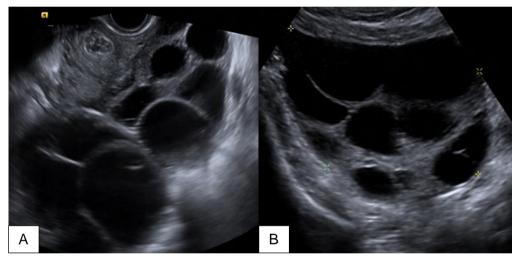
A 36-year-old female patient with a history of ovarian stimulation treatment came to the emergency department reporting pelvic pain. Transvaginal ultrasound is performed observing both ovaries (image A and B) with increased dimensions, as well as multiple follicles of multifocal and bilateral distribution, compatible findings are ovarian hyperstimulation syndrome.
